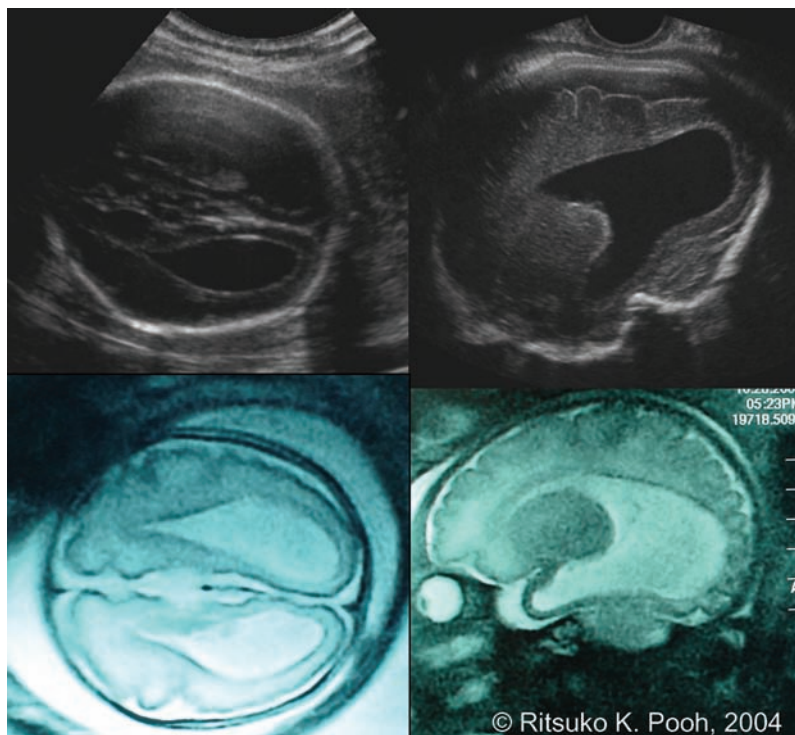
Fetal ultrasound and MR images of characteristic ventricular shape in a case with agenesis of the corpus callosum. (Upper left) Ultrasound axial image. (Upper right) Ultrasound parasagittal image. (Lower left) MR axial image. (Lower right) MR parasagittal image. Note the tear-drop appearance of the lateral ventricles in the axial section. Ventricular appearance in the parasagittal section is called 'colpocephaly'.
